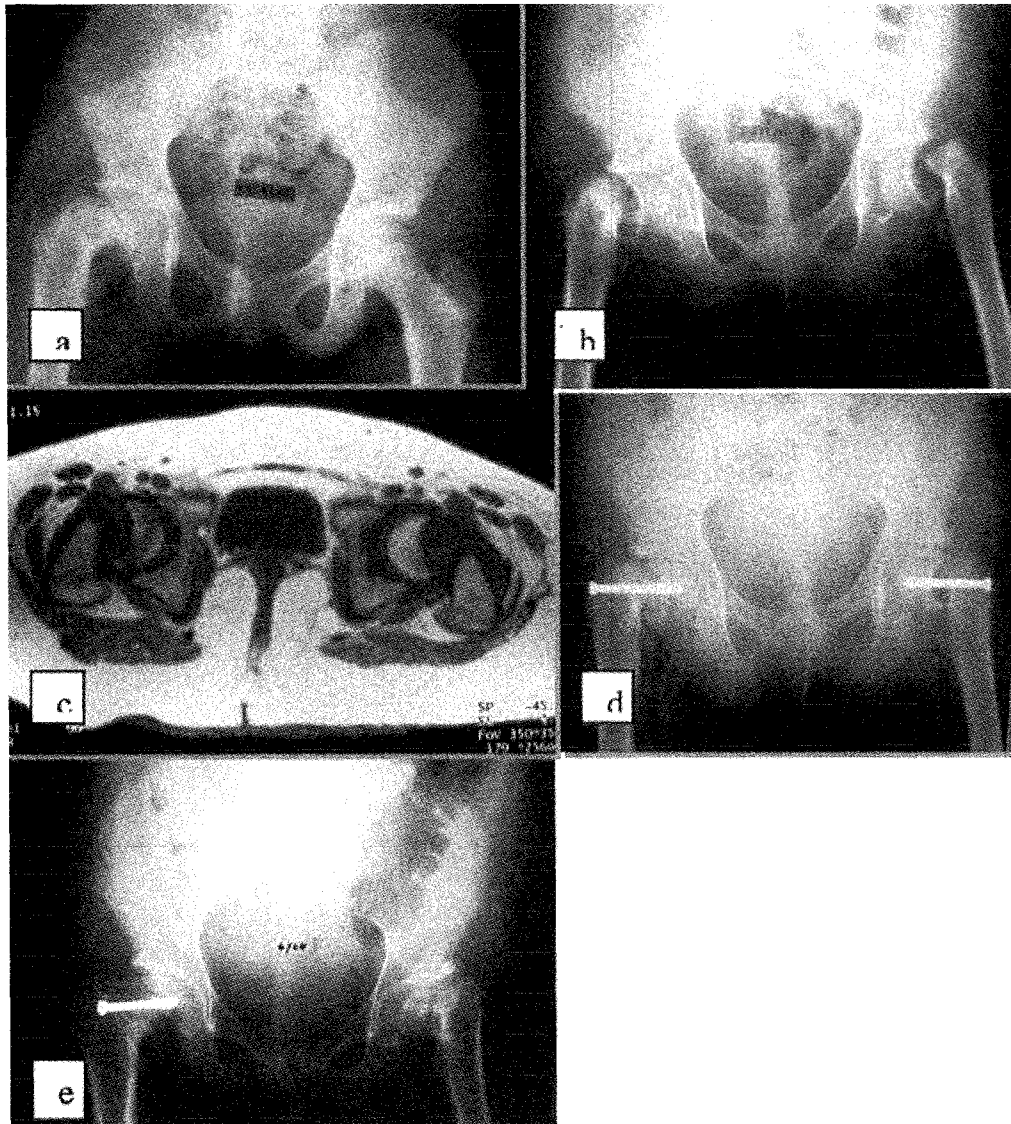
(Case 13) - A 12 year-old girl presented with one month history of right knee pain. (a) The radiograph showed a chronic, severe slip of the right capital femoral epiphysis and normal looking left hip. She developed left knee pain five day after admission. (b) Radiograph depicted an acute severe slip of the left capital femoral epiphysis. (c) Magnetic resonance imaging showed a large AVN of the right femoral head and a small AVN of the left femoral head. (d) The right hip had an in situ cannulated screw fixation while the left hip had a gentle closed reduction before cannulated screw fixation. (e) Nineteen months after surgery, the left femoral head had collapsed due to AVN and the screw was removed. The proximal physis of the right femur has closed.
